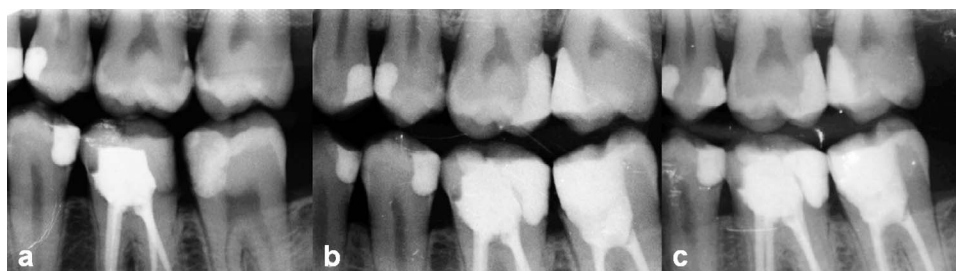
X-rays of maxillary left first and second molar; #14 indirectly capped with mineral trioxide aggregate, #15 indirectly capped with $\text{Ca}(\text{OH})_2$. (a): Preoperative stage. (b): 12 months. (c): 24 months.
